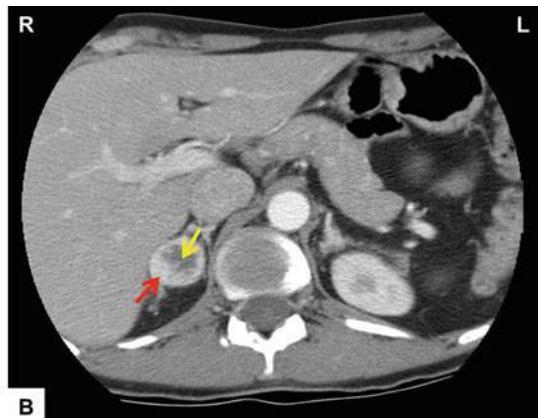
Adrenal computed tomography images of a 31-year-old male with classic salt-wasting congenital adrenal hyperplasia who was incidentally found to have an adrenal mass. (a) The lesion appears heterogeneous, with ill-defined borders and a precontrast density of 26 Hounsfield Units (HU) in the center, and 35 HU at the periphery of the lesion (white arrow). (b) The postcontrast
